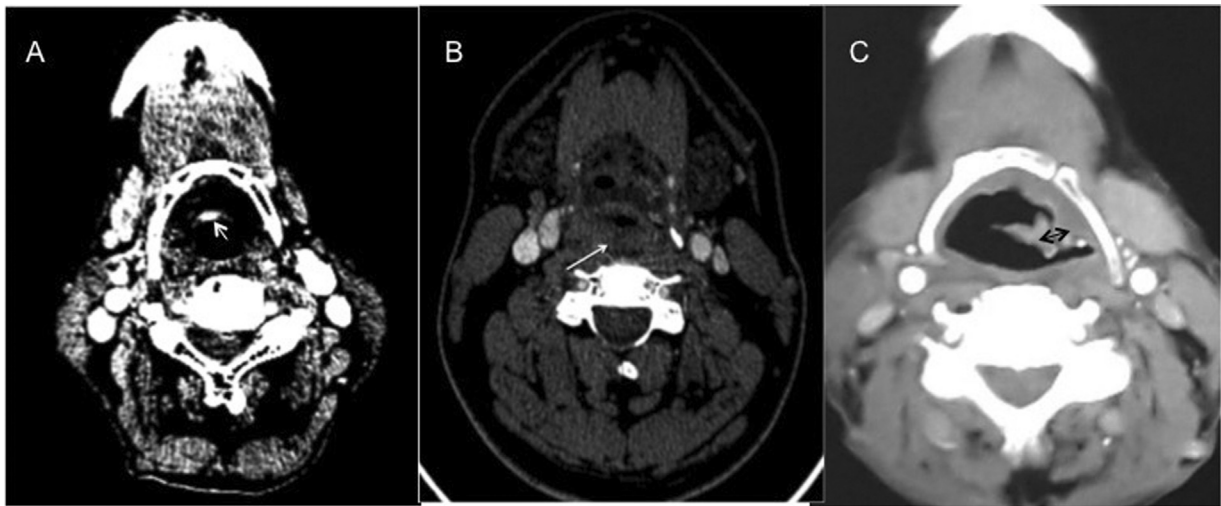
Follow-up computed tomographic scans of postradiotherapy supraglottic carcinoma. (A) Neck Imaging-Reporting and Data System (NI-RADS) 2a—anterior focal mucosal enhancement (*short arrow*), negative for recurrent disease. (B) NI-RADS 2b—nonenhancing increased soft tissue bulk (*white arrow*). (C) NI-RADS 3—irregularly thickened epiglottis and supraglottic mucosa on the left side (*double black arrow*).
